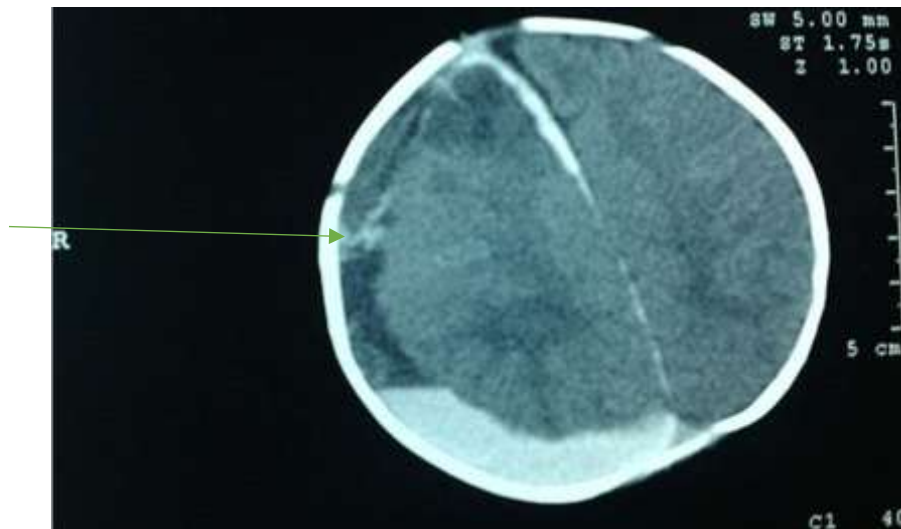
Representative Cranial CT scan.
